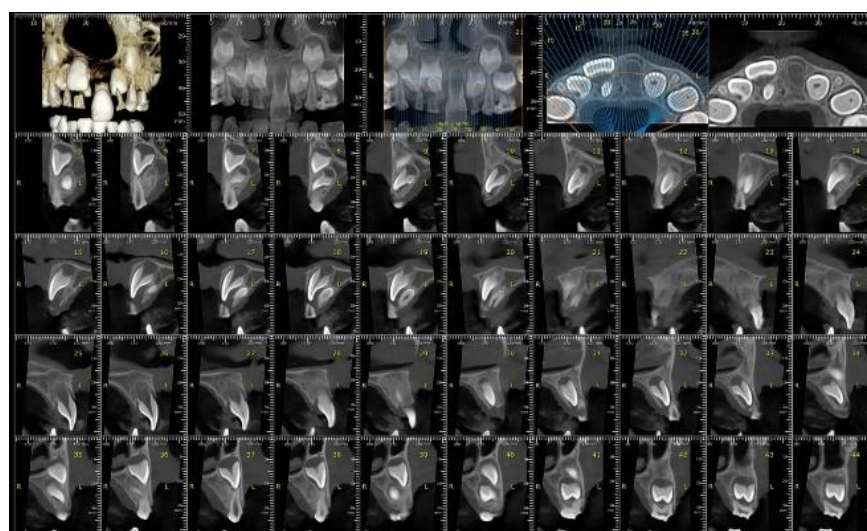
CBCT examination, February 2023, for three-dimensional evaluation of the position of the mesiodens and its relationship with tooth 1.1.
